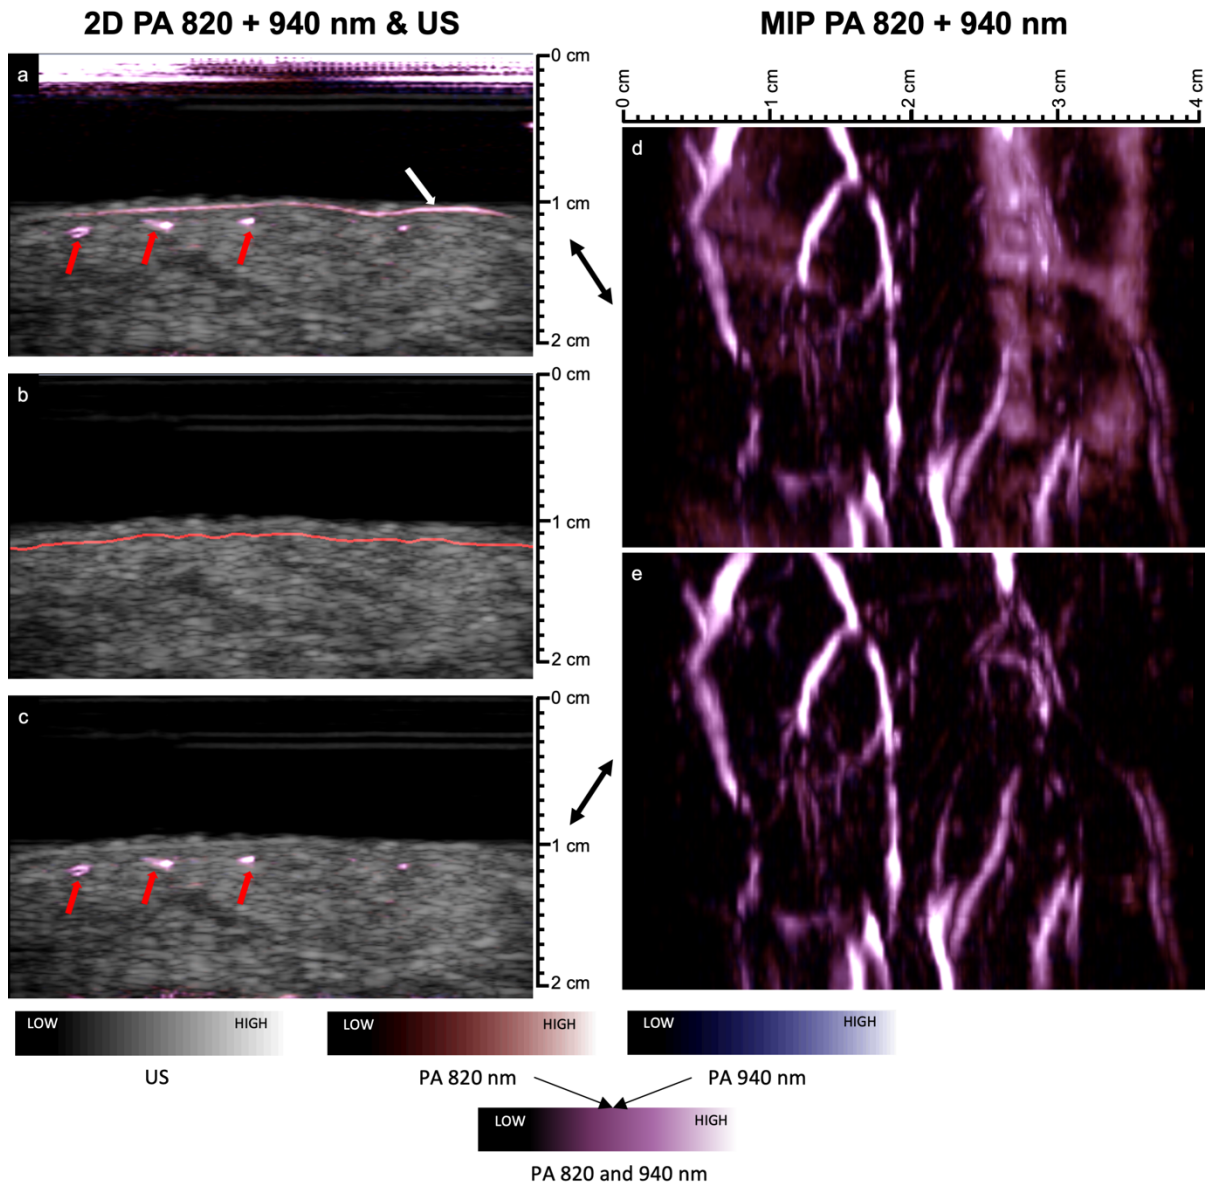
Photoacoustic (PA) and ultrasound (US) images of blood vessels in the volar forearm. (a) Combined 2D axial photoacoustic and ultrasound image without surface suppression. Red arrows point to blood vessels and white arrows to the skin melanin signal. (b) Demonstration of the detected skin surface (red line) above which all photoacoustic signal is suppressed. (c) Combined 2D and photoacoustic image with surface suppression. Red arrows point to blood vessels. (d) Maximum intensity projection (MIP) without surface suppression corresponding to the 2D image in panel a. (e) Maximum intensity projection with surface suppression corresponding to the 2D image in panel c.
